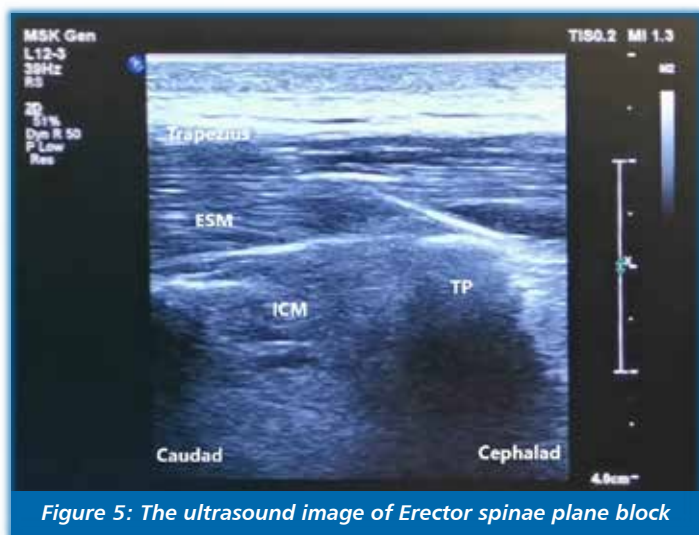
The ultrasound image of Erector spinae plane block
